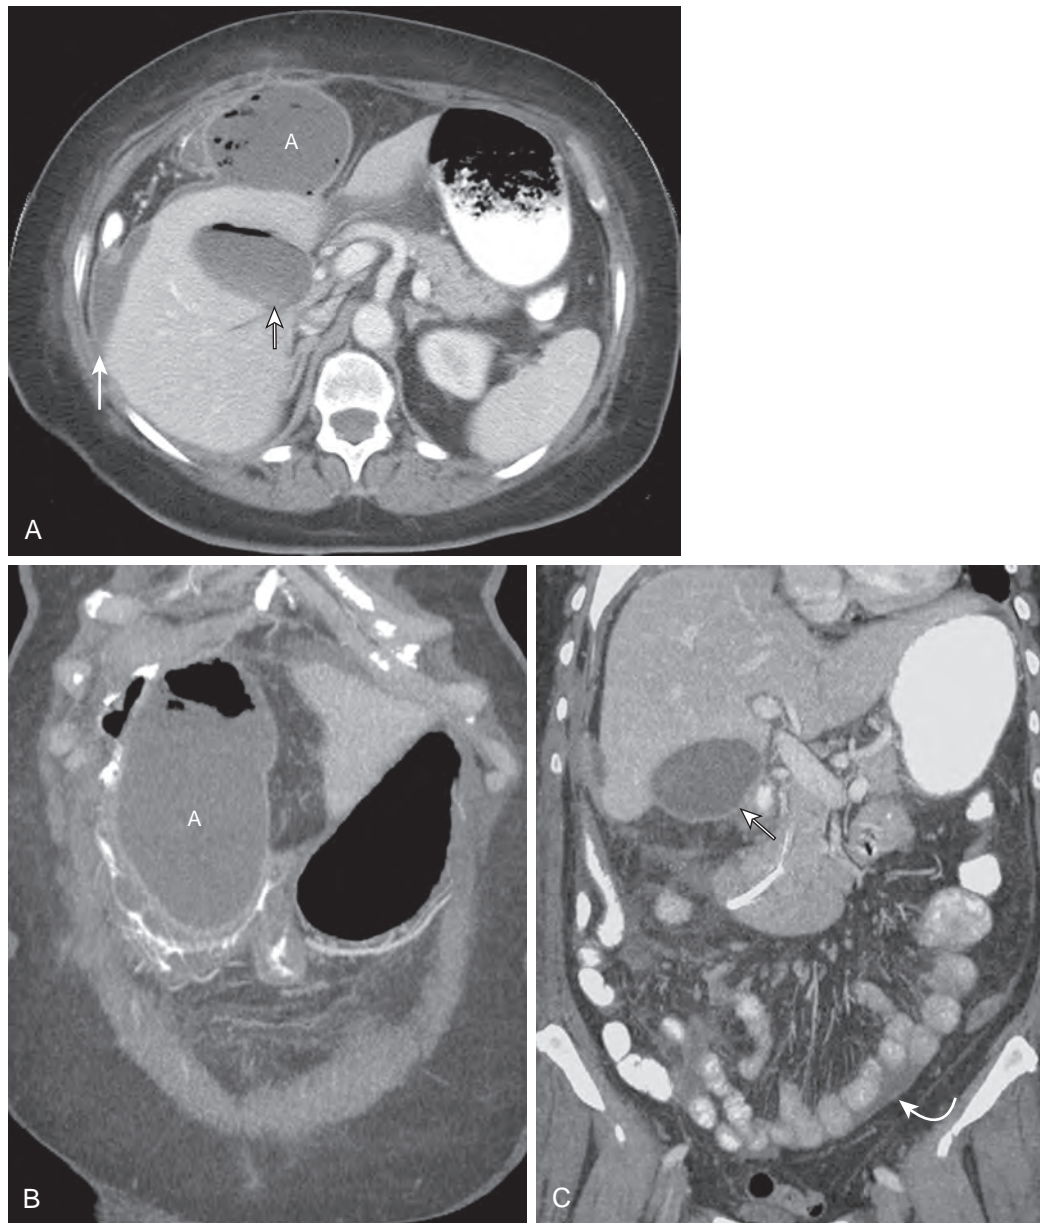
Postoperative abscess after LC. A. Contrast-enhanced CT shows gas-containing abscess anterior to liver (A). Fluid and gas in gallbladder fossa (short arrow). Fluid around liver (long arrow). B. Coronal reformat shows full extent of abscess cavity (A). C. Coronal reformat shows fluid in gallbladder fossa (straight arrow) and pelvis (curved arrow).
